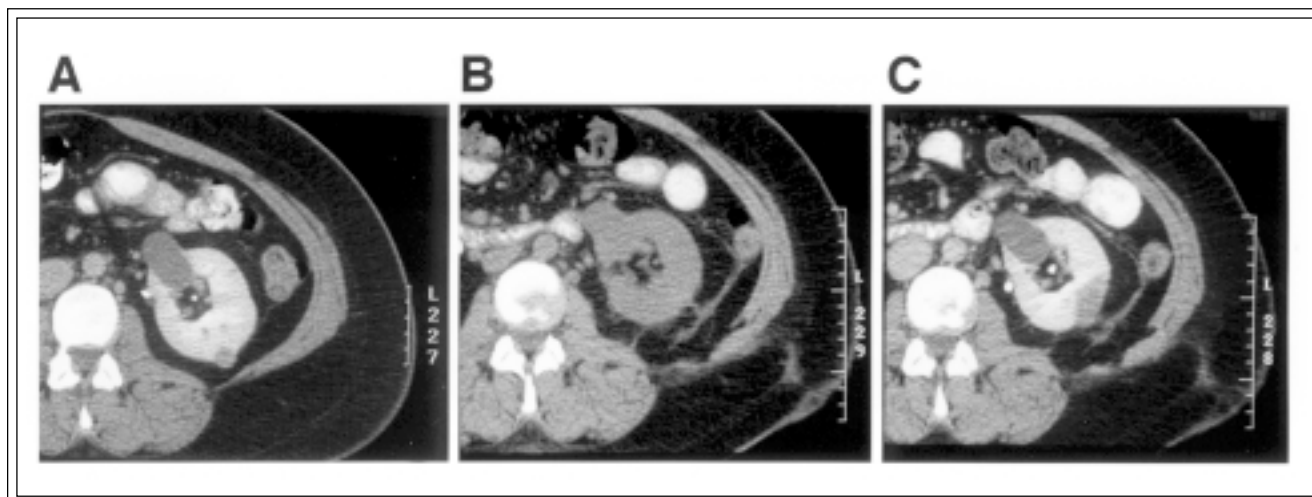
Renal tumor. Panel A: Contrast CT prior to RFA treatment revealed an enhancing solid renal tumor (Δ HU+27). Panel B: On follow-up non-contrast CT, the treated lesion appeared hyperdense. Panel C: After contrast administration, the treatment zone no longer enhanced (Δ HU+2) and measured 3.3 cm x 1.7 cm. The size of the treatment zone suggests that some collateral damage to adjacent renal parenchyma occurred during the RFA treatment.
